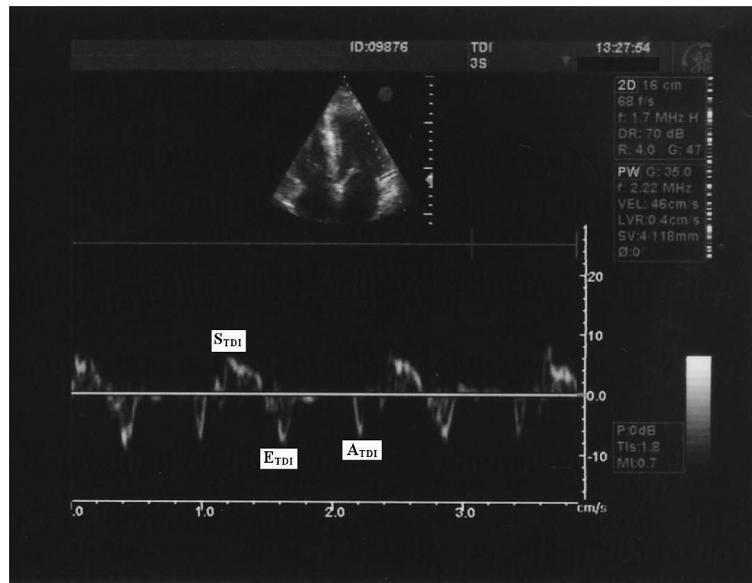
Measurement of tissue Doppler parameters recorded in a patient with essential hyperhidrosis.  $S_{TDI}$ , systolic velocity;  $E_{TDI}$ , early diastolic velocity;  $A_{TDI}$ , Late diastolic velocity.
